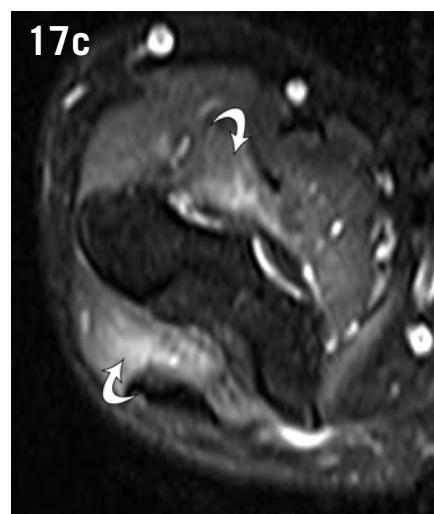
Radial nerve compression. Axial T2-weighted fat-suppressed images at the level of the humeral spiral groove (a and b) and the level of the elbow joint (c). In (a), the ulnar nerve has normal size and signal (white arrowhead) and is starting to cross the lateral intermuscular septum (white arrow). At a slightly more distal image, there is increased signal and thickening of the radial nerve (black arrowhead). There is denervation edema of the brachialis and supinator muscles.
